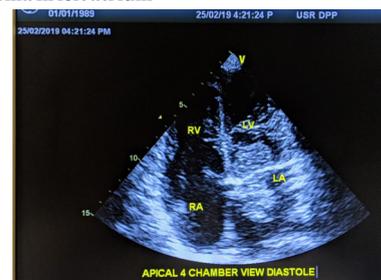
Apical 4 chamber view on 2D Echocardiography LA myxoma prolapsing in LV during diastole.
